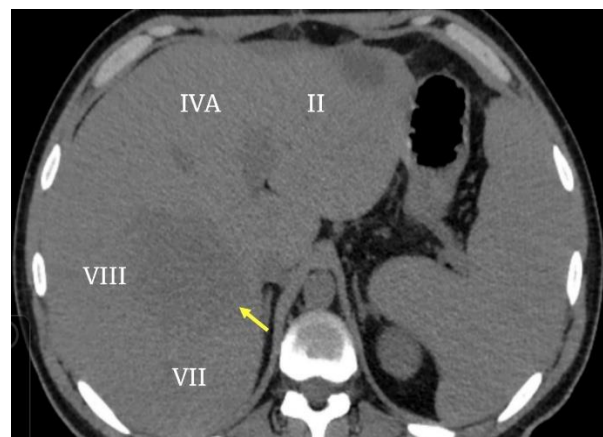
Abdominal computed tomography (CT) after surgery. Axial section of abdominal tomography, showing decrease of hepatic lesions in segment VIII (arrow) and in segment II, III, IVA.
